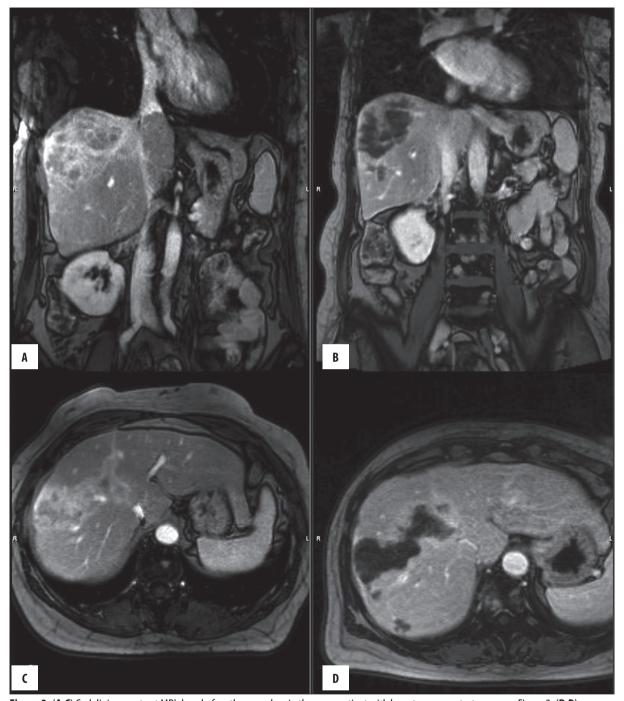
(A,C) Gadolinium contrast MRI done before the procedure in the same patient with breast cancer metastases as on Figure 2, (B,D) gadolinium contrast MRI control after DEM TACE, extraction of the vascularization of the tumor.
